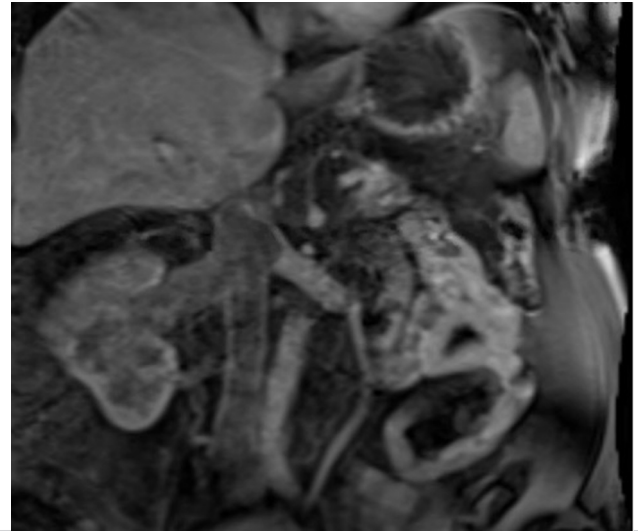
Coronal view of magnetic resonance image of abdomen with evidence of inferior vena cava (IVC) extension.
